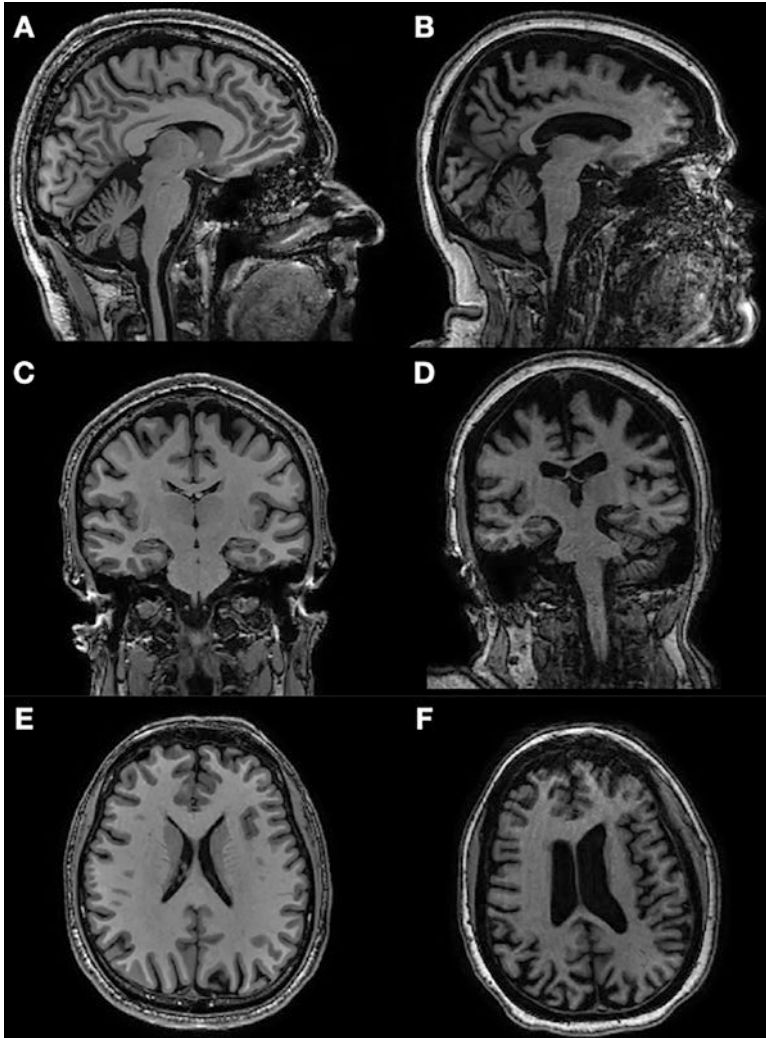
Brain MRI T1 sagittal (a, b), coronal (c, d), and axial (e, f) sequences of a control (left) and a patient with neurodegenerative disease (right) showing brain volume reduction in the latter. (Courtesy: Dr. Thiago M. Cordeiro)
